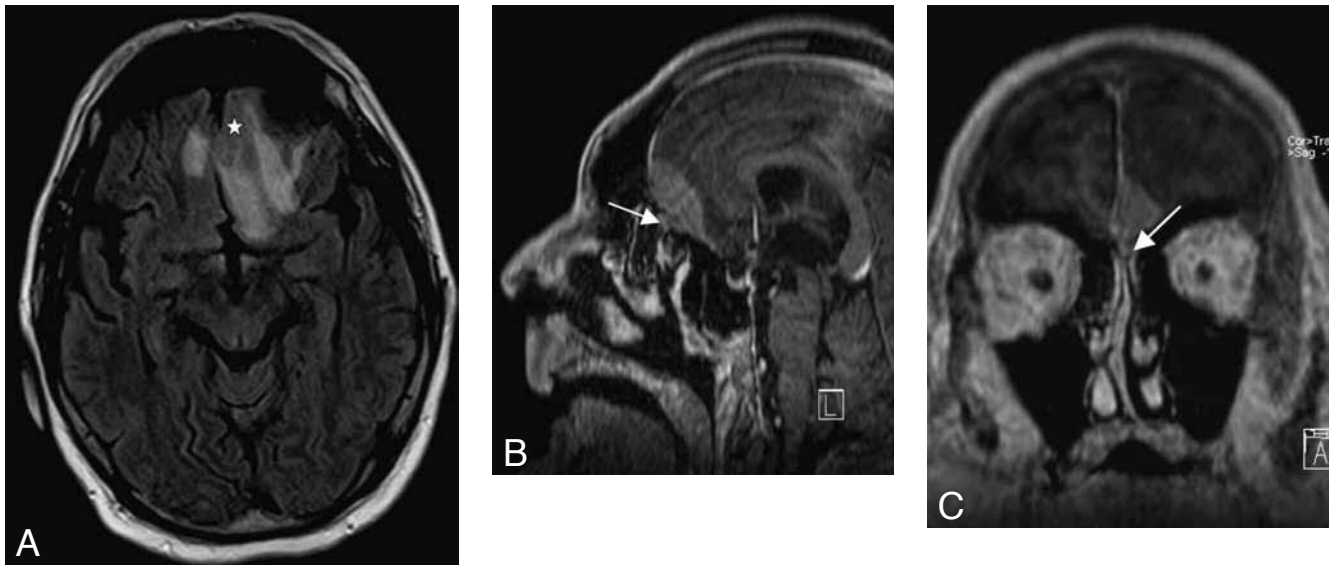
Axial FLAIR (A) and T1-weighted MR acquisition after gadolinium administration, with sagittal (B) and coronal (C) reconstructions, showing the ENB (asterisk) above the cribriform plate and surrounding edema. Enhancement is moderate to intense. A small extension along the nasal septum is present (white arrow).
